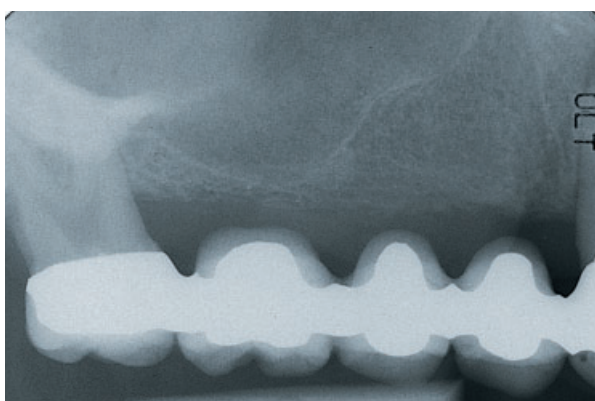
Pre-operative radiograph of the patient's maxillary right posterior segment, revealing a tooth-borne long-span FPD which had failed after 4 years of function due to loss of retention and subsequent damage on the mesial abutment.
